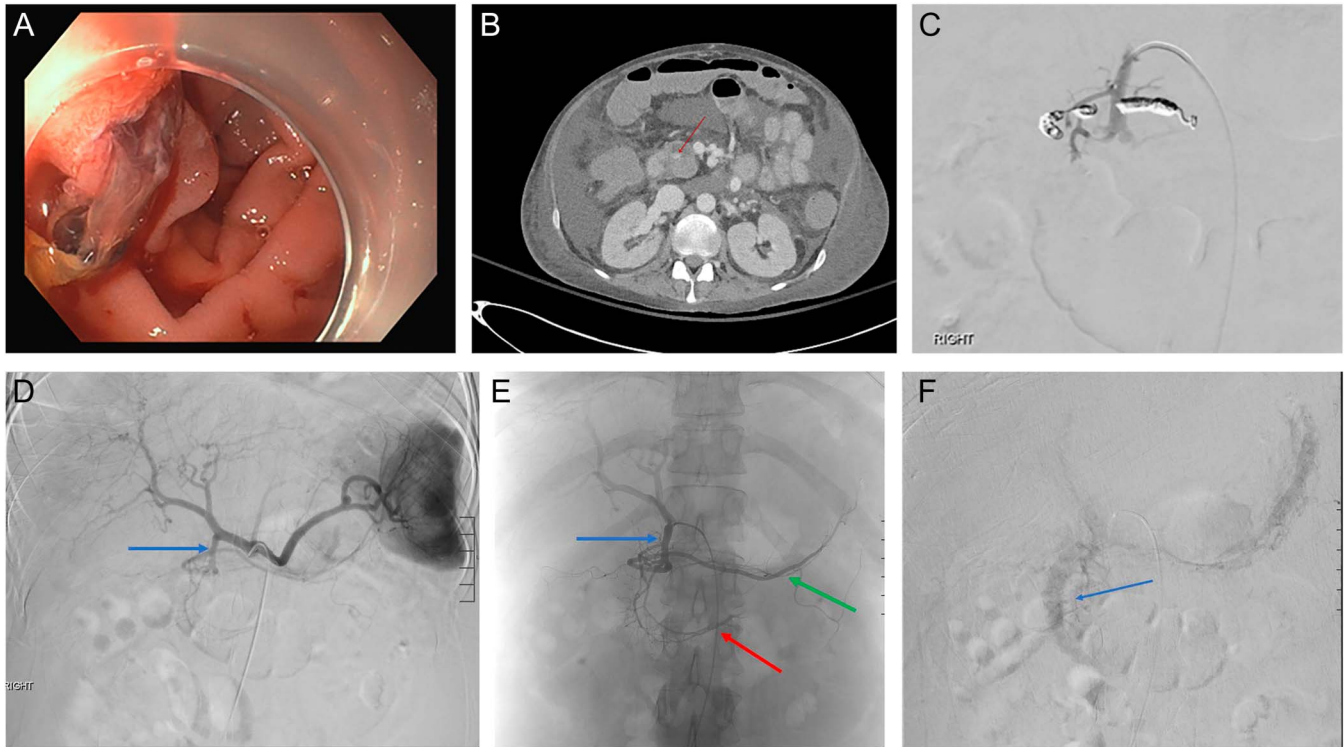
(A) Endoscopic visualization of the proximal duodenum with apparent fresh and clotted blood emanating for the ampulla. (B) Portal phase of a computed tomography angiography series showing a cyst within the head of the pancreas and accumulation of contrast within the cyst indicating active bleeding. (C) Coil embolization of the right gastroepiploic artery and gel foam embolization of the gastroduodenal artery and pancreaticoduodenal arcade. (D) Fluoroscopy showing injection of the celiac axis without evidence of associated aneurysm or pseudoaneurysm. The blue arrow indicates the gastroduodenal artery. (E) Fluoroscopy showing direct injection of the gastroduodenal artery without evidence of associated aneurysm or pseudoaneurysm. The blue arrow indicates the gastroduodenal artery, the red arrow the pancreaticoduodenal arteries, and the green arrow the transverse pancreatic artery. (F) Delayed fluoroscopy after injection of the gastroduodenal artery demonstrating contrast blush along the second part of the duodenum indicating active bleeding as indicated by the blue arrow.
